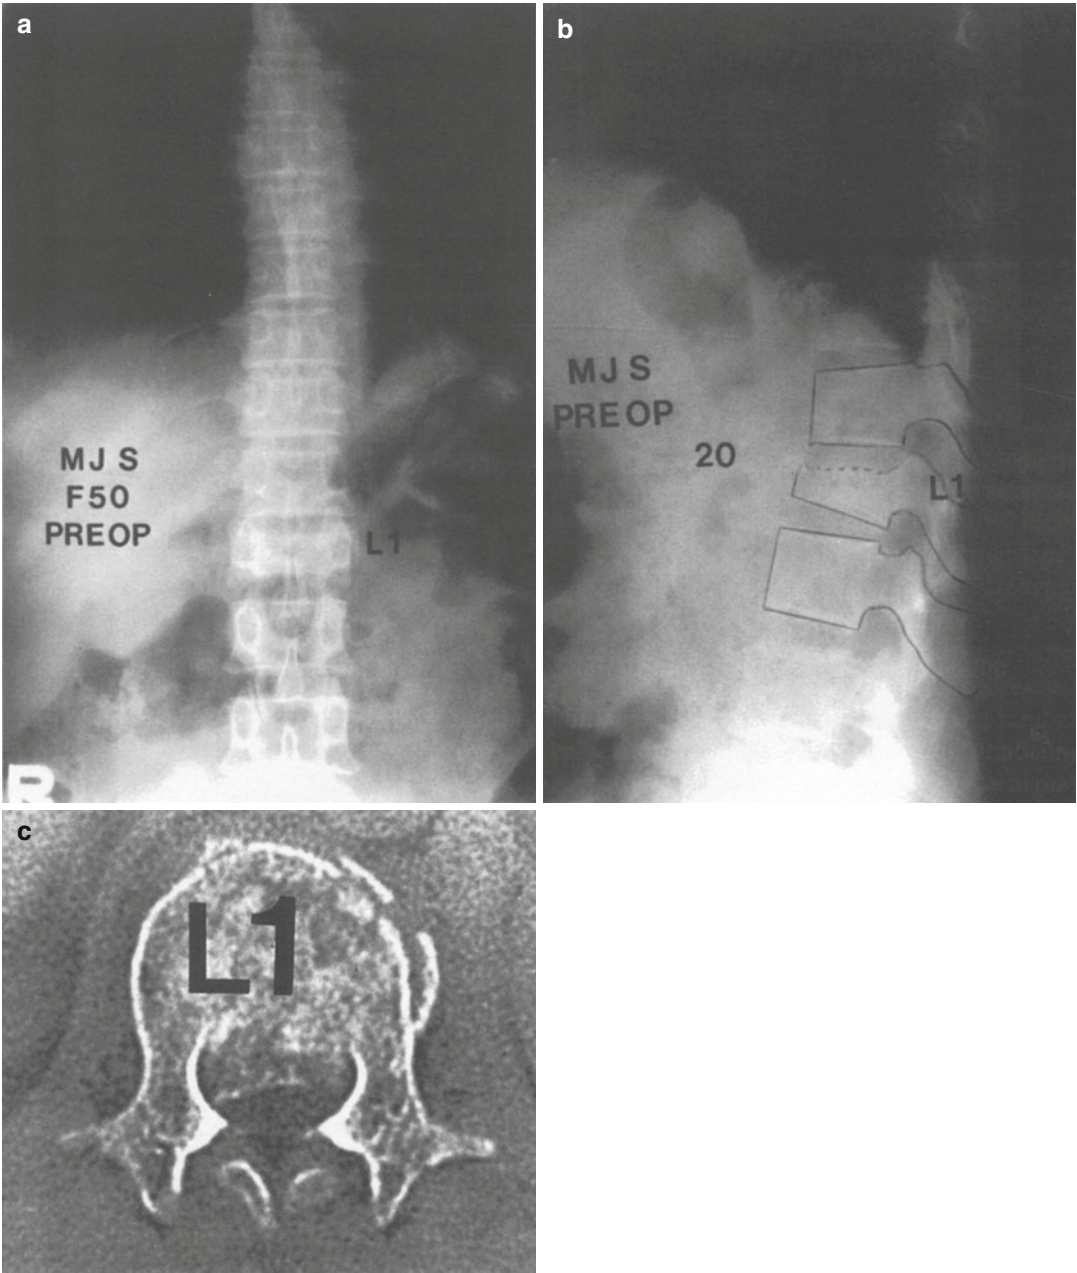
(a, b) A 50-year-old female with L1 unstable burst fracture. There was a 20° kyphotic deformity at the thoracolumbar junction. (c) Preoperative CT show 40 % canal encroachment. (d, e) She was treated by posterior
